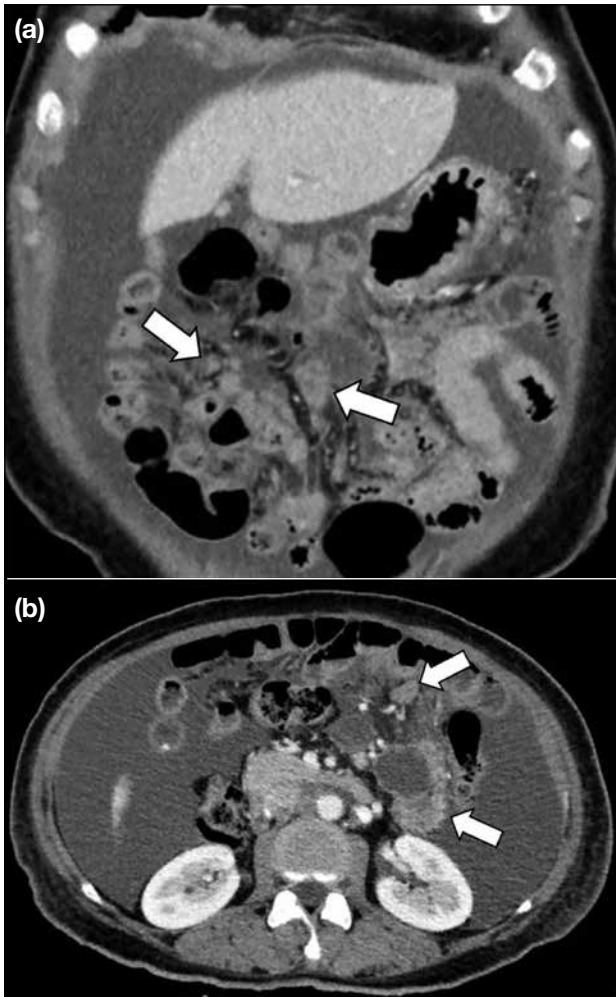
(a) Coronal and (b) axial images from contrast computed tomography demonstrating nodular deposits at the mesentery (arrows).
